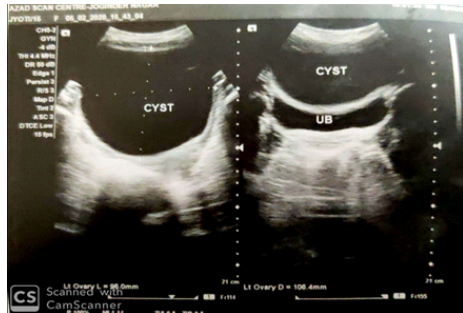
Ultrasonography revealed a completely anechoic lesion suggestive of a purely cystic consistency. Note the absence of septatae.
